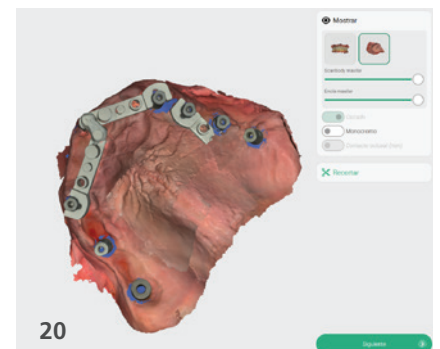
Temporary restoration placed at the 12-hour follow-up visit. – Fig. 17: Radiograph at the three-month follow-up. – Fig. 18: Restoration at the three-month follow-up visit. – Fig. 19: Soft-tissue healing after three months. – Fig. 20: Final digital impression.
